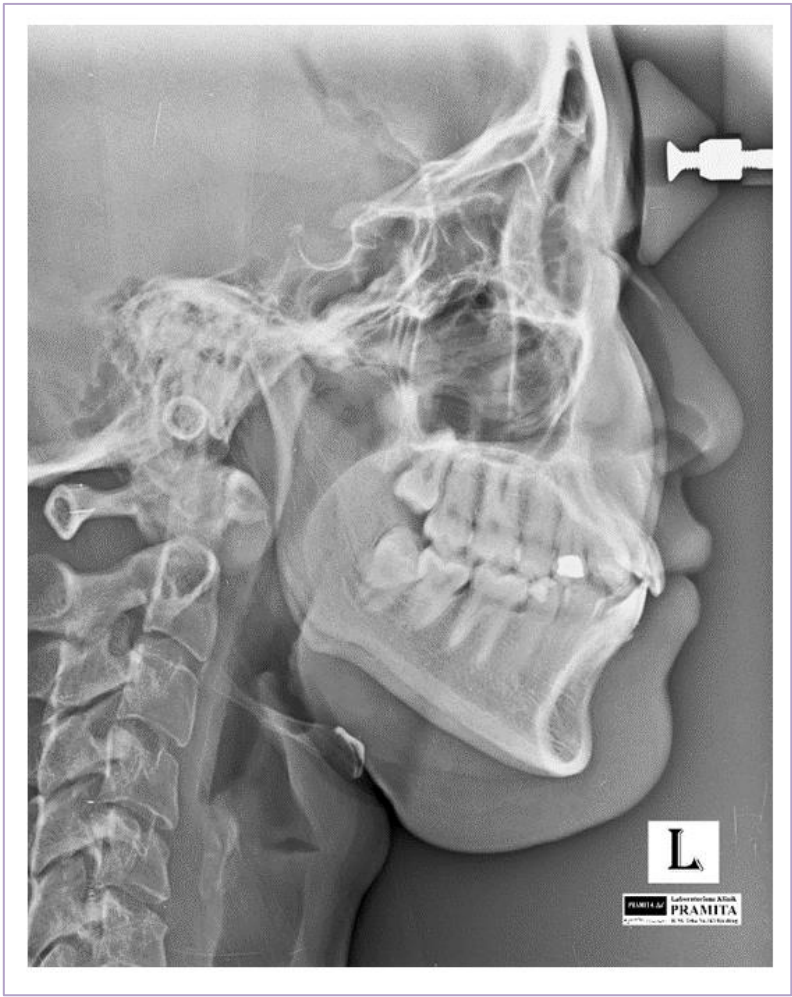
Lateral cephalometric radiograph before orthodontic treatment
